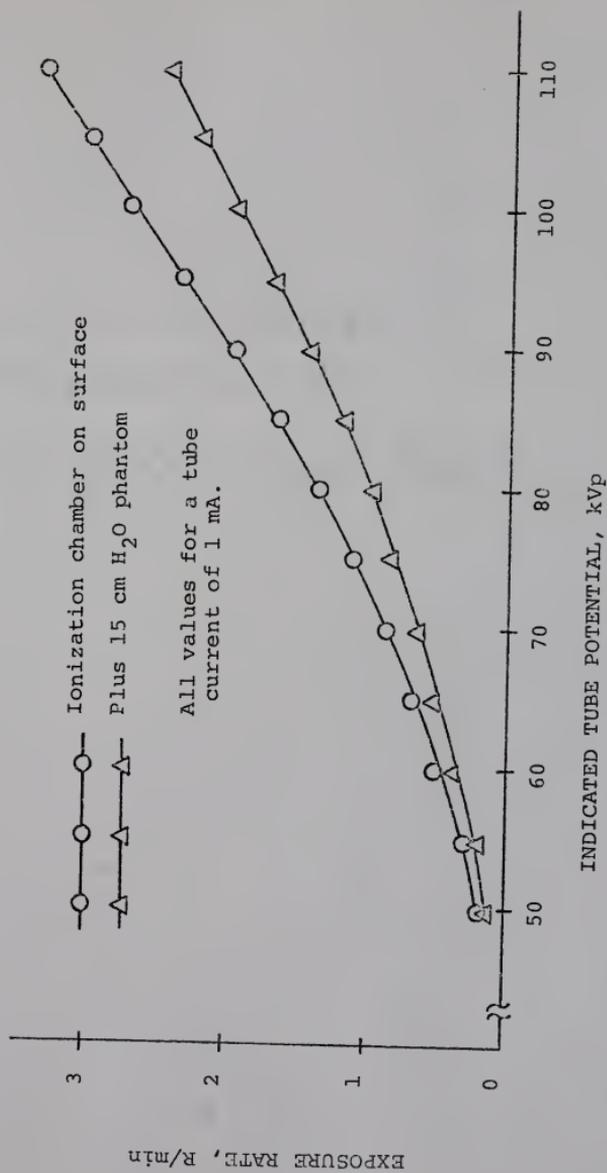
Measured Exposure Rate at Flat Table Surface From Under Table Fluoro/Cine X-ray Tube.
